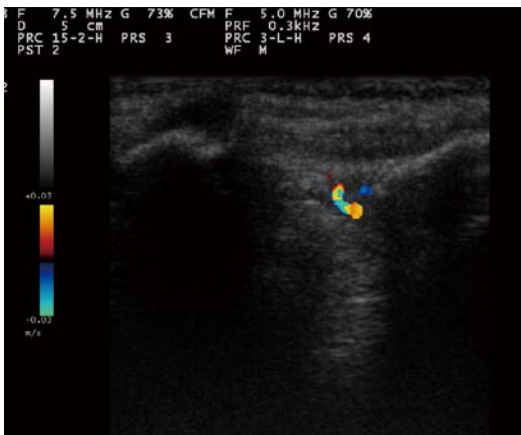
Color Doppler sonogram of sacroiliac joint in a patient with active sacroiliitis reveals vascularization within the posterior portion of the right sacroiliac joint.
